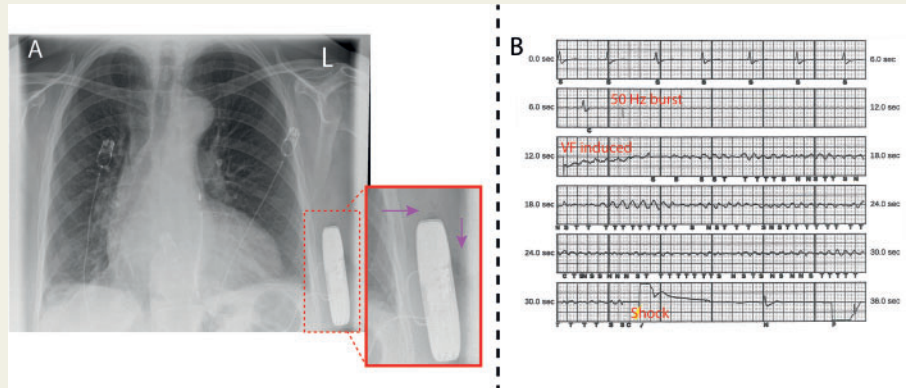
Chest X-ray (CXR) and successful defibrillation threshold (DFT) test. (A) There is loculated air trapped within the pulse-generator pocket (purple arrows) causing an abnormally high shock impedance. (B) A week after the generator substitution, repeat DFT test was performed: delivery of a 50 Hz burst for 5 s induced VF which was appropriately sensed and defibrillated to sinus rhythm using 40 J of energy; the shock impedance had reduced from 135 Ω to 98 Ω . VF, ventricular fibrillation.
